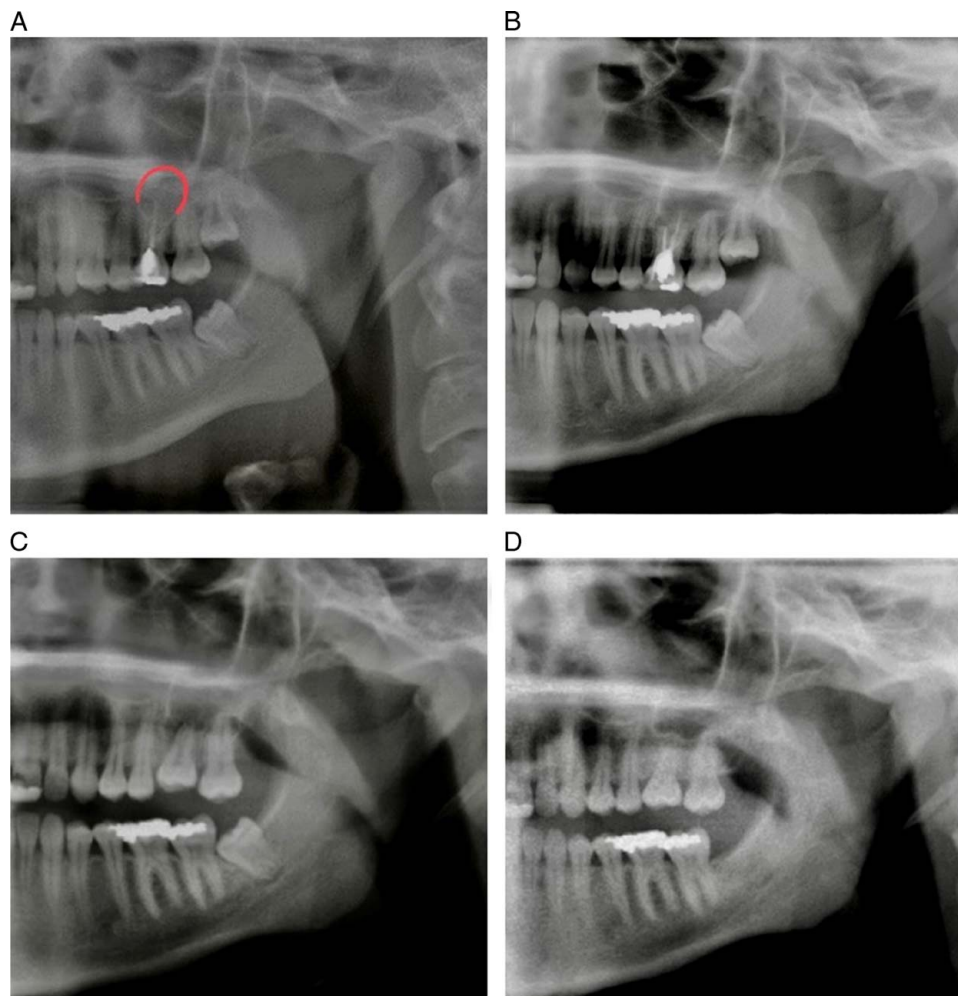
(A) Panoramic radiograph (OPG): parodontitis apicalis + radicular cyst tooth 26. (B) OPG: tooth 26 after root-tip resection. (C) OPG: tooth 28 was transplanted in region 26. (D) OPG: recall after 1 year.
